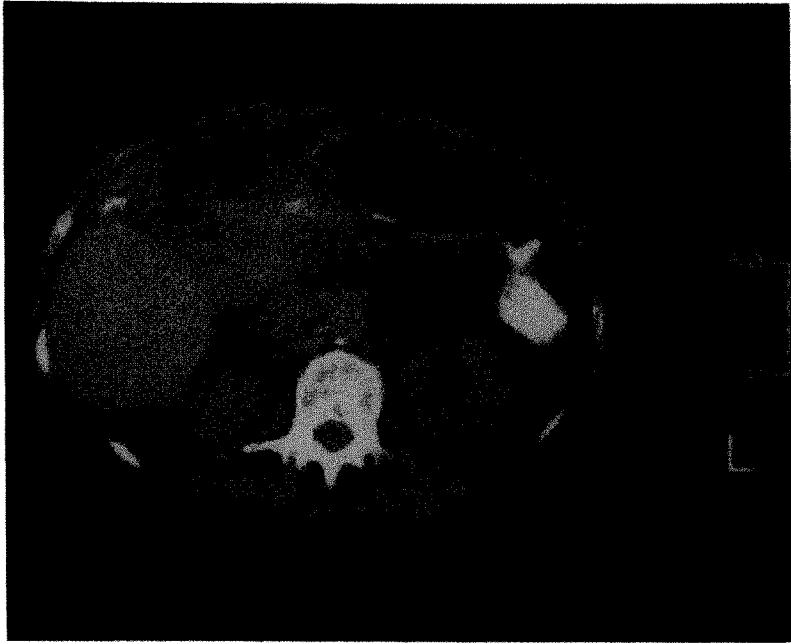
Non-enhanced abdominal CT, showing a mixed attenuation mass surrounding the common bile duct, anterior to and continuous with the head of the pancreas, obscuring both the gallbladder and duodenum.
